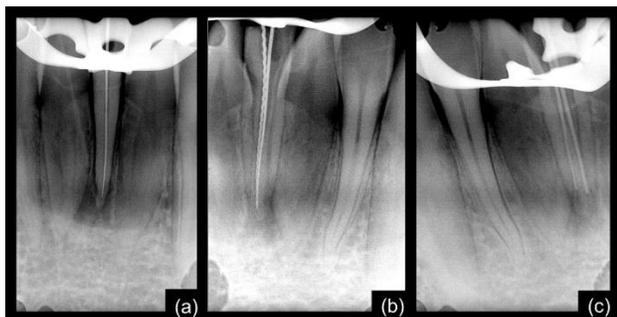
(A and B) Periapical radiograph showing the working length estimation of 31 from two different angulations. (C) Radiographic confirmation of master apical fit in relation to 31.
